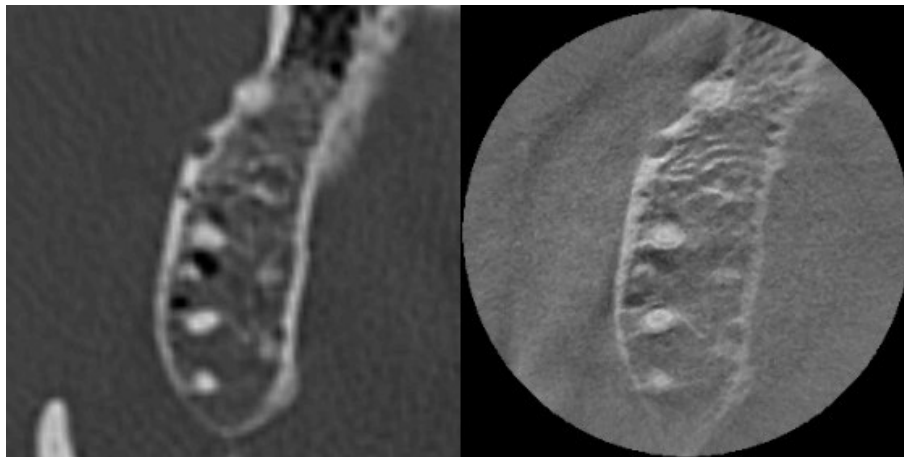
Co-registered MSCT (left) and CBCT (right) images of dataset 2 (Accuitomo 3D, posterior maxilla). The CBCT image is an original axial slice as acquired by the scanner, whereas the MSCT image was created by reslicing the 3-D image data volume according to the registration transformation between both images. While the cortical bone is clearly outlined in the MSCT image, local differences in contrast can be perceived in the Accuitomo 3D CBCT image, which complicates its segmentation by a global threshold.
